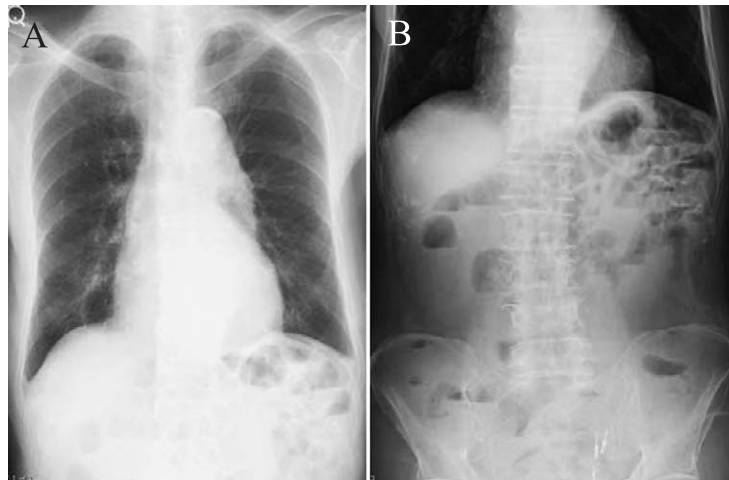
Abdominal radiography on Day 7 of hospitalization
